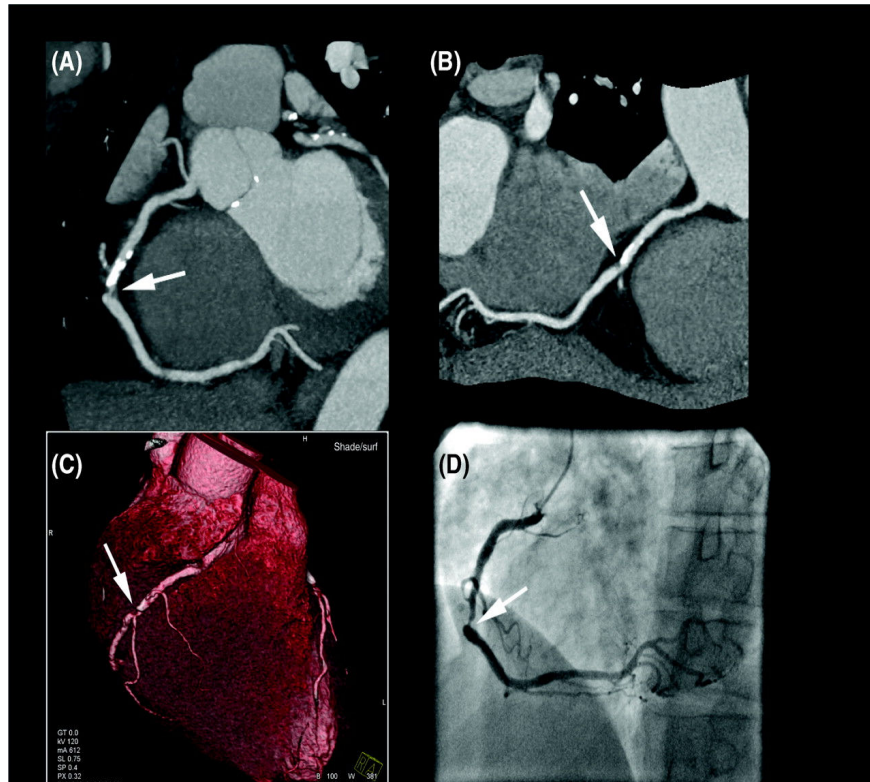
Coronary artery stenosis detection with multi-detector row computed tomography.
